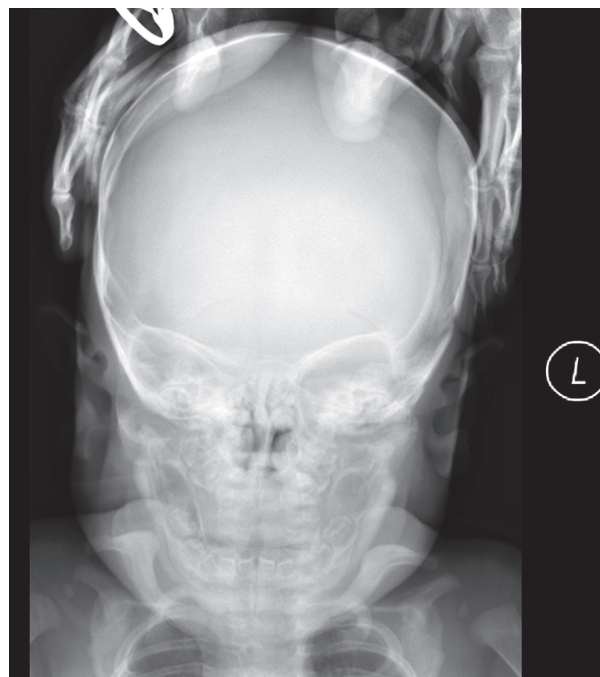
Babygram. Anteroposterior radiograph of the skull showed bones smoothly scratched
